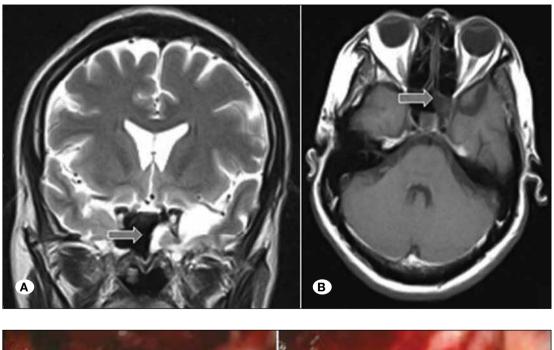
Preoperative cranial MRI scans (A) T2 coronal and (B) T1 axial slices. The arrow shows Sternberg 's canal, brain tissue protruding into the sphenoid sinus, and accompanied by CSF signal, about the size of 1.3 x 1.4 cm.
